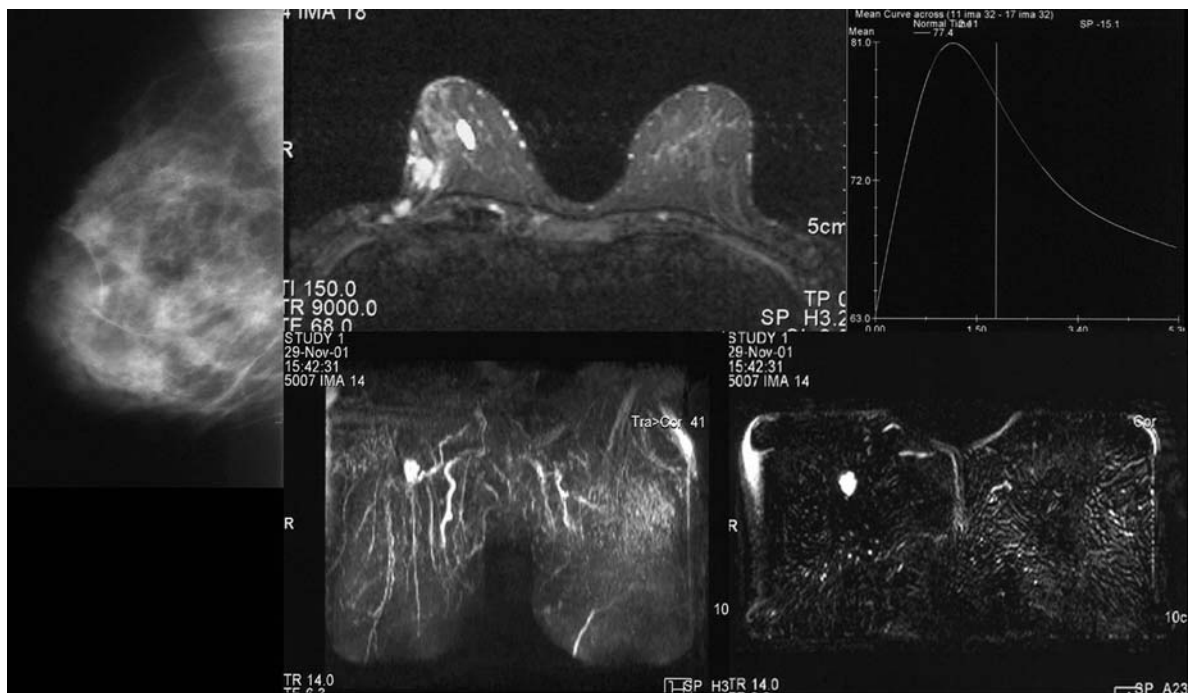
Example of carcinoma highlighted at MRI in mammographic dense breast
